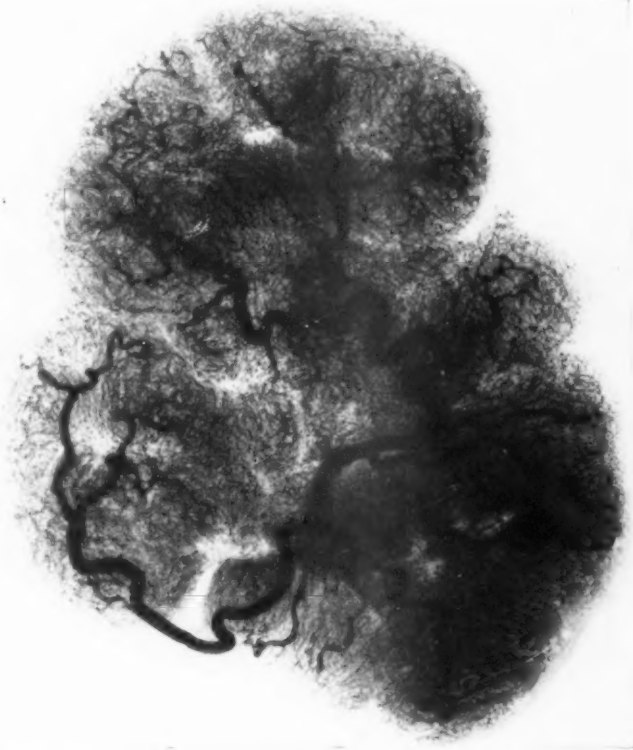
Roentgenogram of placenta (flat plate). No measurable circulatory arrest due to infarct formation.
